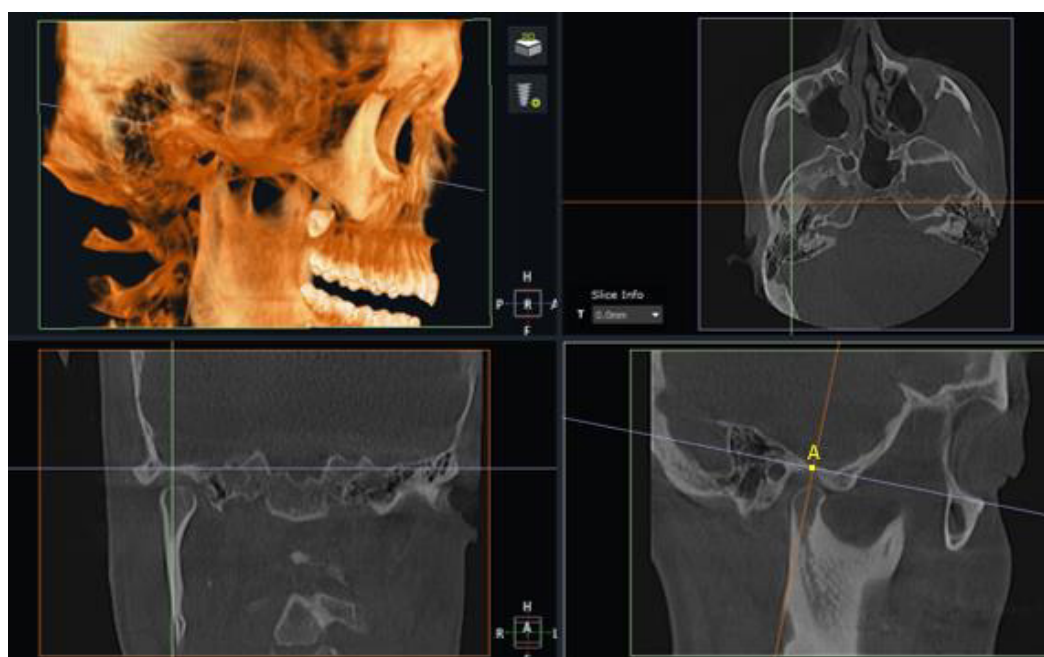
CBCT showing section having superior most and medial most point in the coronal view and superior most and anterior most point in sagittal view as point A.
